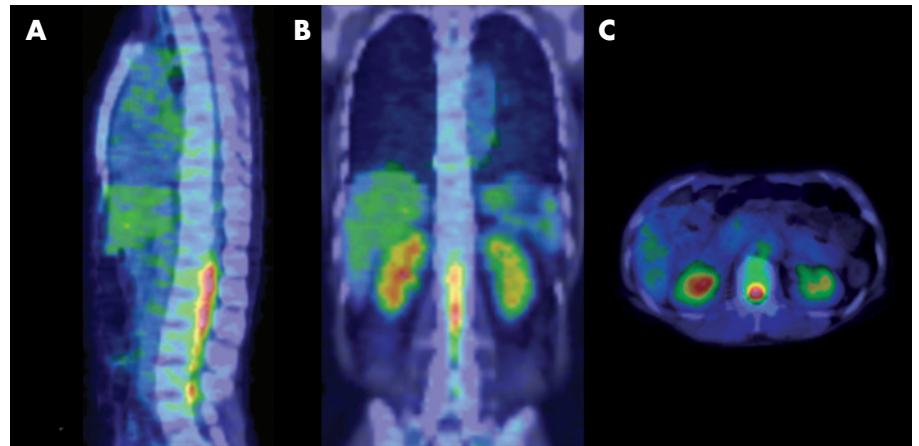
(A) Sagittal, (B) coronal and (C) axial fused fluorodeoxyglucose (FDG)-positron emission tomography-CT images show increased FDG uptake in the spinal canal, corresponding to the magnetic resonance image.
